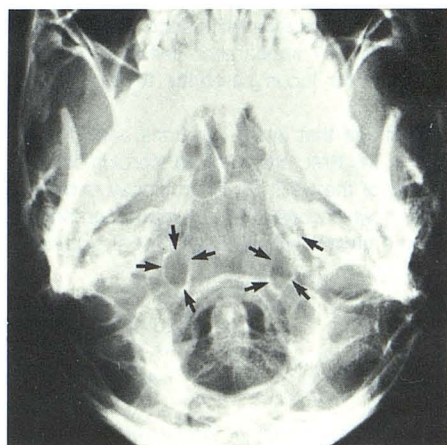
Plain film demonstration of bilateral pseudofoamina, more prominent on right (arrows).
